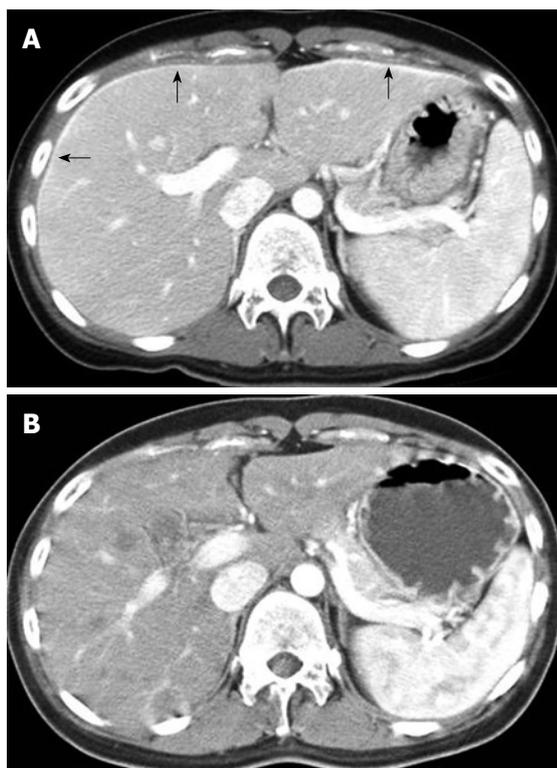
Contrast-enhanced CT. A: Linear enhancement of the surface at both lobes of the liver (arrow); B: CT images 1 mo after treatment indicate normal liver.
